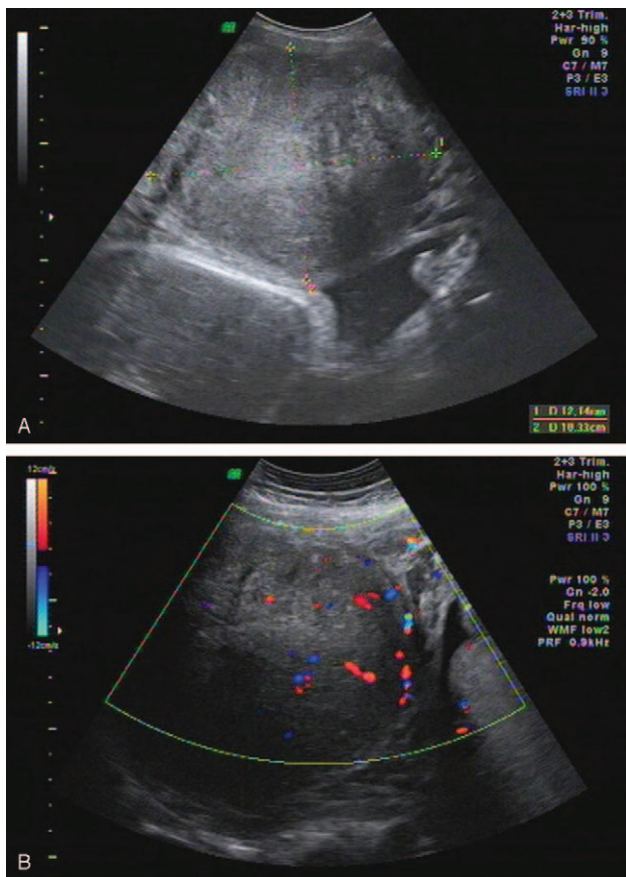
Conventional US was shown at 18+4 weeks. The maximum size of the tumor was 15.1 cm × 10.3 cm × 12.1 cm (953.4 mL) (A). Color Doppler US shows the circle blood flow signal within and around the uterine myoma (B).
